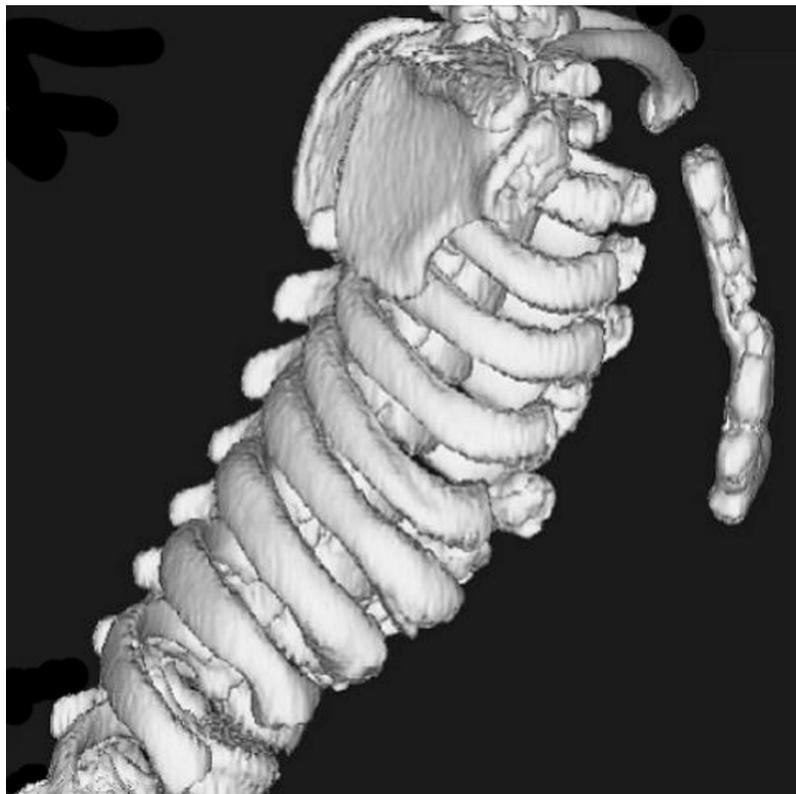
3D reconstruction of a CT scan of the bony thorax of a patient with Jeune syndrome.
